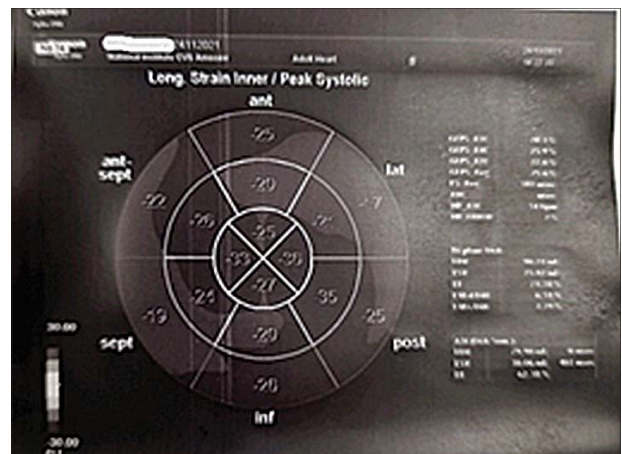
Stress echocardiography before pharmacology probe (after LMCA stent placement)
